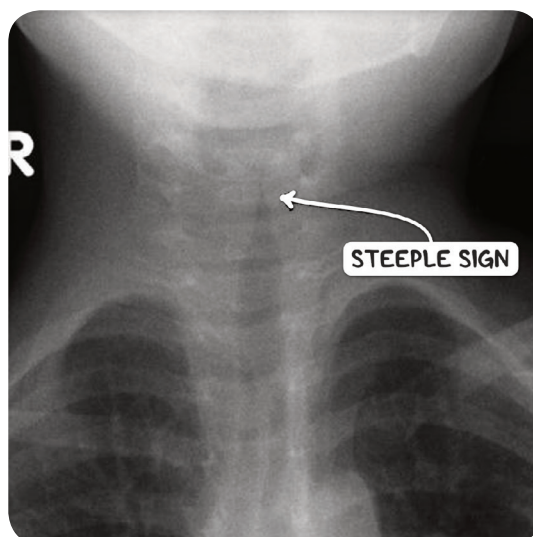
A plain X-ray image demonstrating the steeple sign in an infant with croup.
